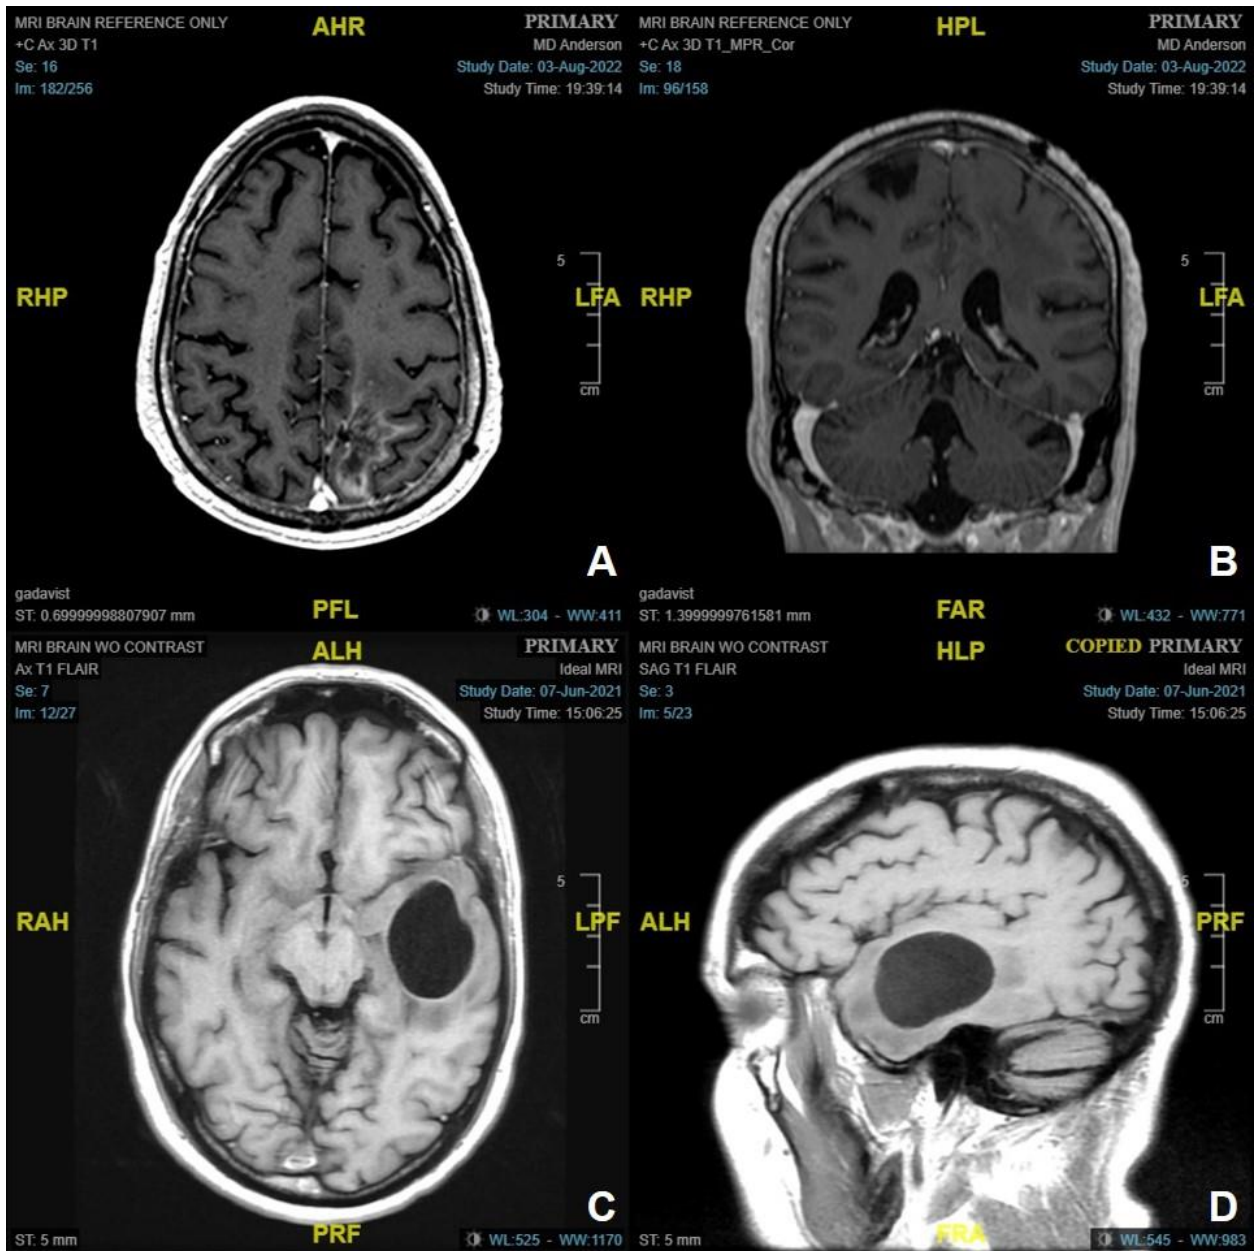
T1 weighted Magnetic resonance imaging (MRI) demonstrates destructive GBM lesions. The first case shows a 2.6 cm left superomedial parietal lesion in Transversal (A) and Coronal (B) view. The second cases shows a 4.4 cm left temporal cystic lesion in Transversal (C) and Sagittal (D) view.
